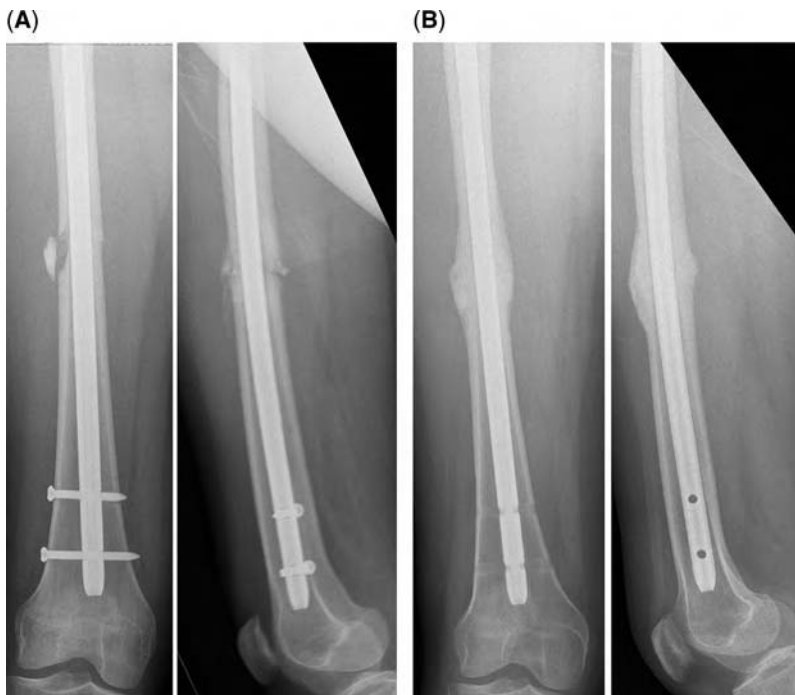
(A) Presenting anteroposterior (AP) and lateral radiographs of a 17-year-old girl with cerebral palsy referred in 3.5 months following intramedullary nail fixation of a femoral shaft fracture. The patient complained of progressively worsening pain in the right thigh. (B) Follow-up AP and lateral radiographs five months following nail dynamization show solid union. At follow-up, the patient is asymptomatic and has returned to preinjury functional status.
